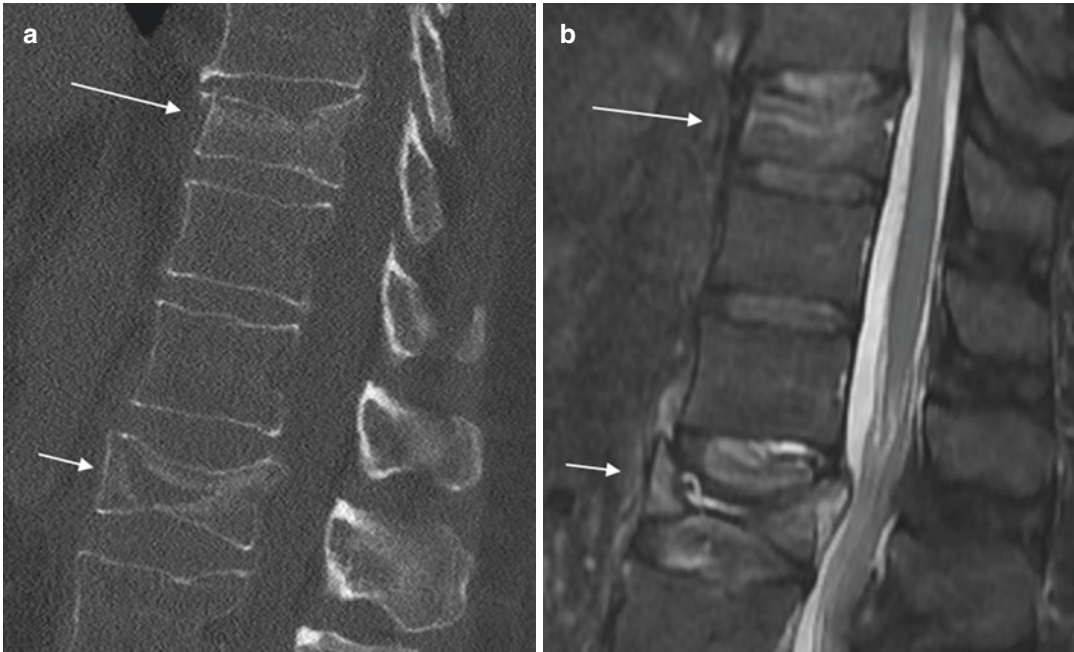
Sagittal CT (a) and T2 fat-saturated MRI (b) images of T10 and L1 compression fractures (white arrows). Axial loading on the flexed spine causes anterior column failure and anterior vertebral body height loss.
